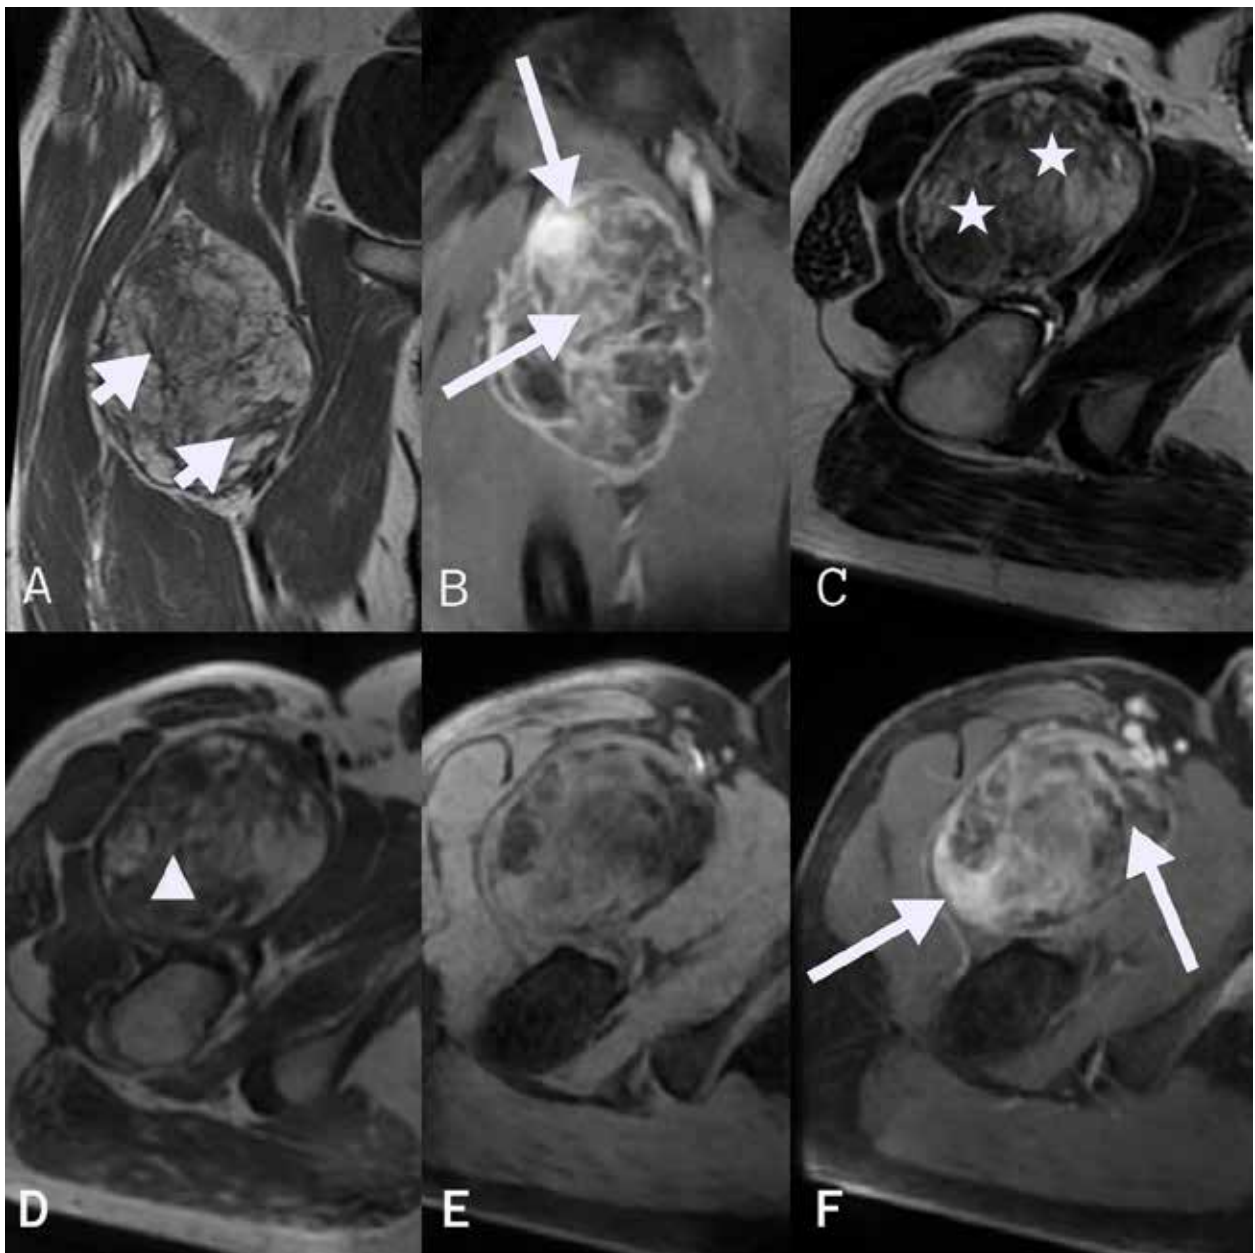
43-year-old male patient with an atypical lipomatous tumor at the right anterior thigh region. (A) Coronal T1-weighted MR (C) axial T2-weighted MR (D) axial T1-weighted MR images with thick septa (>2mm)(short arrows) and less than 75% fat containing component (arrow head and asteriks) (B) Coronal and (F) axial fat-suppressed postcontrast T1-weighted MR images show heterogeneous and nodular enhancement (long arrows). (E) Axial fat-suppressed pre-contrast T1-weighted image shows partial fat suppression and with heterogeneous signal higher than subcutaneous fat.
